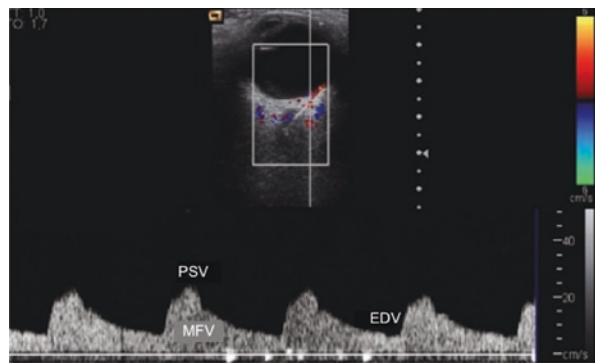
OCCS: PCA in the retrobulbar fat; Typical PCA waveform obtained by PW Doppler shows a blunted peak systolic and low to moderate flow velocity during diastole; (PSV)Peak systolic velocity, (MFV) Mean flow velocity and (EDV) Distolic flow velocity. (Courtesy: Jiménez Aragón et al. [32])
